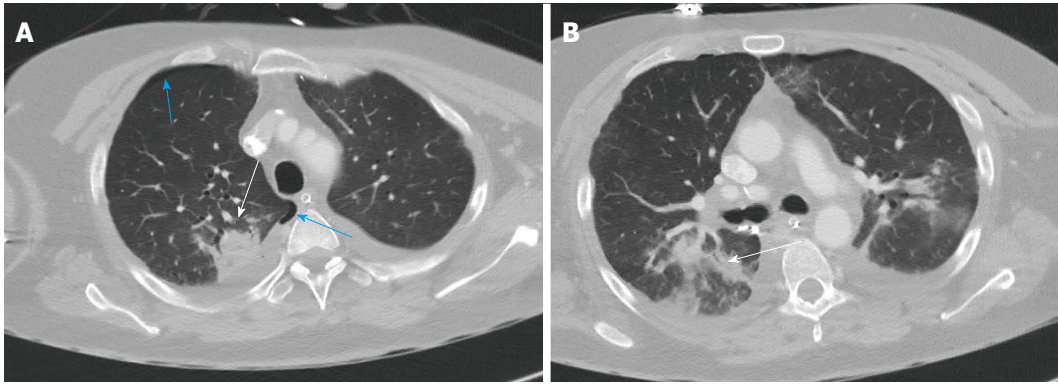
Computerised tomography scan of the chest 2 wk post-transplantation shows consolidation in the right upper lobe posteriorly with air bronchogram in keeping with pneumonia. Associated right sided pneumothorax. A: Axial slice of CT chest showing right upper lobe consolidation (white arrow), and right sided pneumothorax (blue arrows); B: Axial slice showing consolidation on the right upper lobe with air bronchogram (arrow). CT: Computerised tomography.
